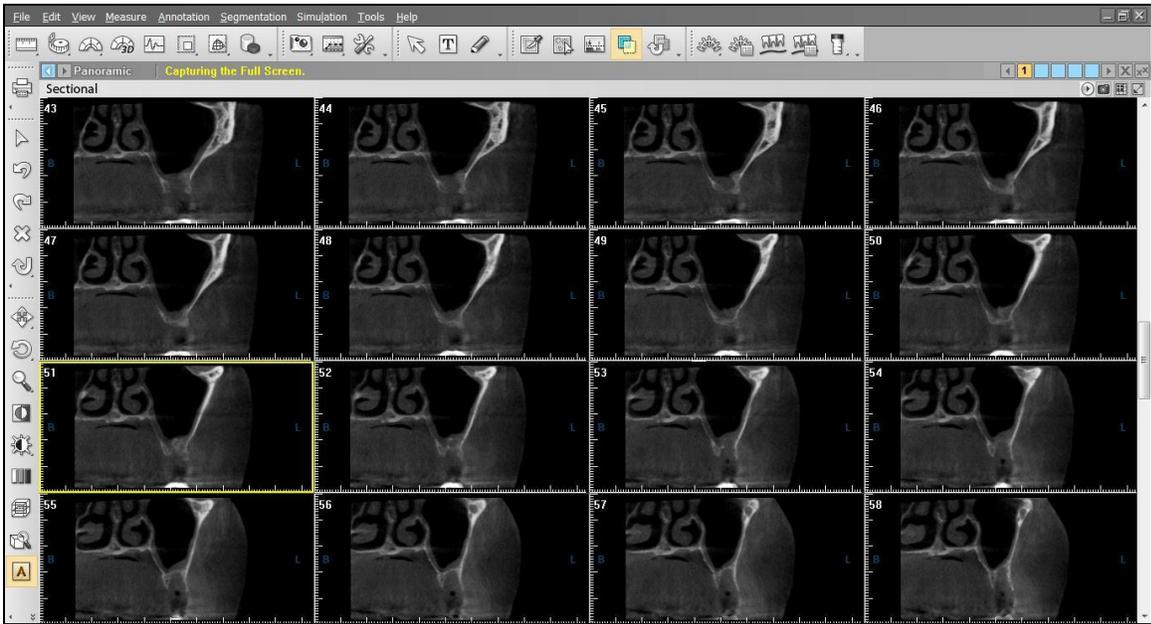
Presurgical diagnostic CBCT.
